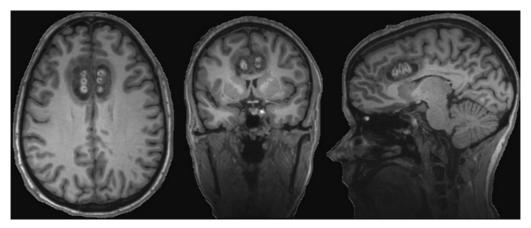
Representative cingulotomy images. Axial, coronal and sagittal T1-weighted MR images (left to right).
